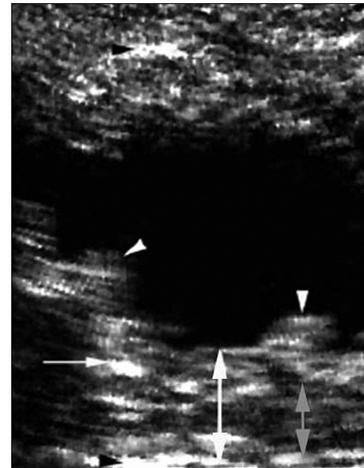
Sample sonogram of normal duodenum
